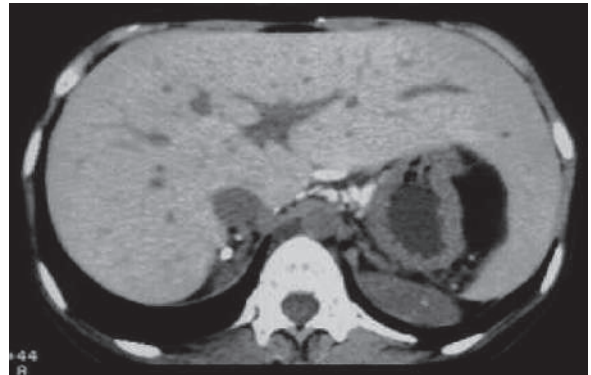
Axial nonenhanced CT of the abdomen shows hepatomegaly with left liver lobe hypertrophy
